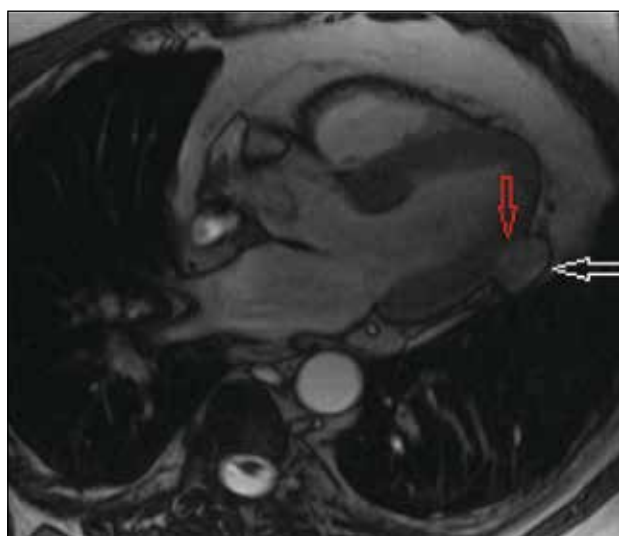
Three-chamber cardiac magnetic resonance image of a 77-year-old male patient with known renal cell carcinoma showed the presence of a pericardial mass (white arrow) at the level of mid-lateral segment of the left ventricle. The tumour showed slight myocardial invasion at the outermost portion of the left ventricular muscle (red arrow).
